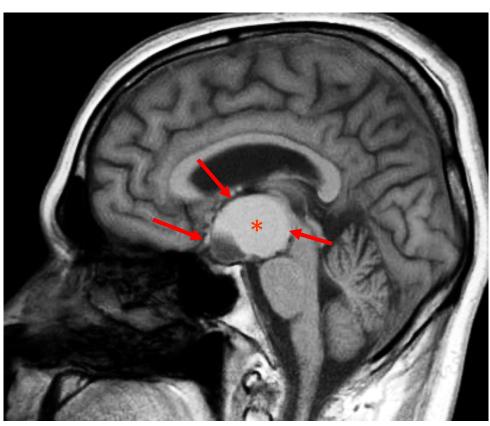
Craniopharyngioma (arrows) on a sagittal T1-weighted image. Note the large cystic hyperintense component (asterisk).
